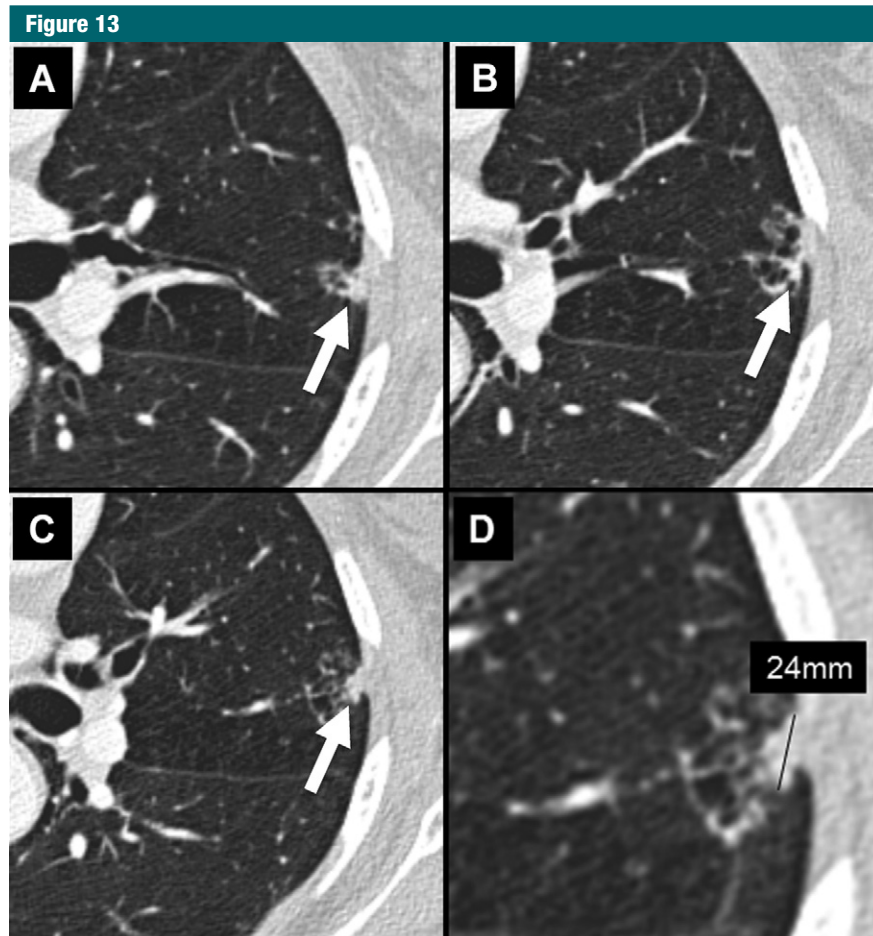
Transverse CT sections through a complex adenocarcinoma with cystic components in the lingula. Measurement of the solid component is challenging in such cases. *A–C*, The length of the largest substantial solid component is indicated (arrow) in each of three representative sections through the nodule. The morphologic complexity and the fact that the nodule abuts the chest wall make measurements difficult. The walls of cystic components may contain some solid elements, but accurate or consistent measurement of such components is often impossible with manual techniques. We recommend selecting the largest nodular solid component for measurement, as shown in *C*. *D*, Detailed view of the nodule shows placement of the measurement anchor points.
